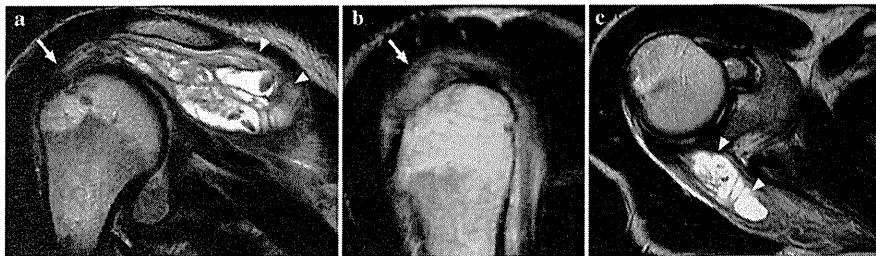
MR findings 23 months after the injury (T2-weighted images: a oblique coronal plane; b oblique sagittal plane, c axial plane). An intramuscular cystic lesion was dramatically enlarged (a, c arrowheads). Note that no capsular structure was seen around the lesion.
